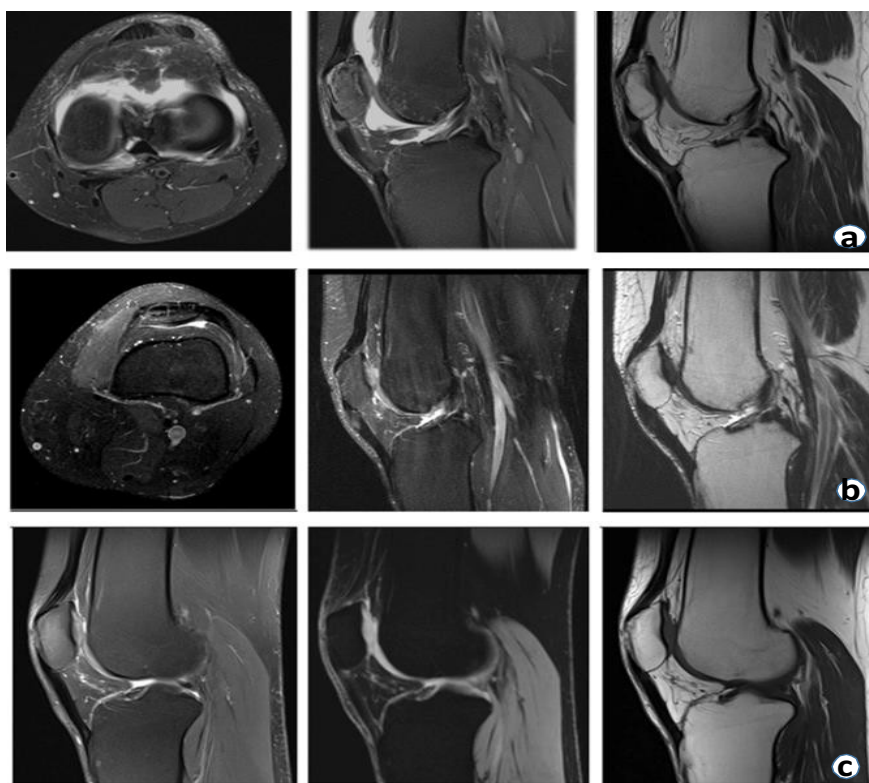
(a) Initial magnetic resonance imaging. (b) Magnetic resonance imaging 4 months after the last RPW session, DP FATSAT axial planes; sagittal T2 FATSAT and sagittal DP where a decrease is identified in the hyperintense area of patellar tendon damage with fiber regeneration. (c) magnetic resonance imaging 12 months after the last RPW session, sagittal planes weighted in DP FATSAT, T2 FATSAT and T1 where generalized integrity is identified in the patellar tendon, without data of previous or remaining injury.
